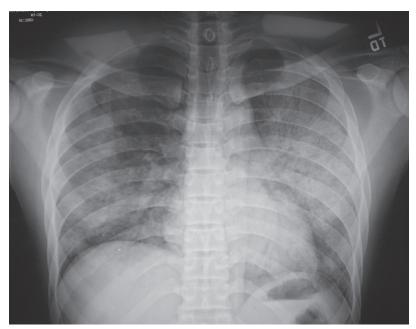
Posteroanterior chest radiograph of a human immunodeficiency virus (HIV)–infected patient reveals interstitial disease mixed with patchy alveolar infiltrates. *Pneumocystis jiroveci* is the most common cause, but bacterial pathogens and tuberculosis also are considered.
